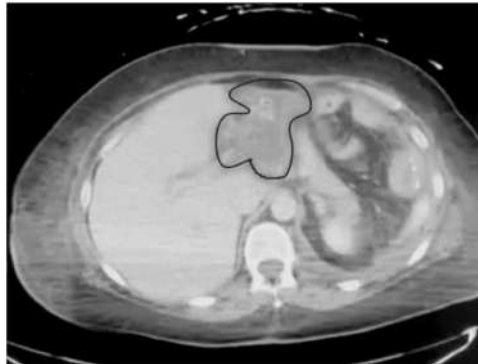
CT showing an hepatic abscess.
